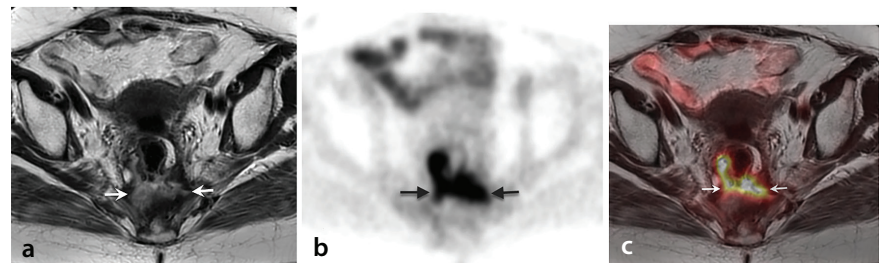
Fluorodeoxyglucose (FDG) uptake in presacral soft tissue after *rectal cancer surgery*. The axial T2-weighted magnetic resonance image (MRI) (a) reveals a lesion of intermediate signal intensity with presacral extension (arrows). The lesion showed diffusion restriction on diffusion-weighted images (not shown). The axial positron emission tomography (PET) (b) and axial fused PET/MRI (c) exhibit high FDG activity (arrows) in the lesion. Pathological FDG accumulation in PET (b) was evaluated in favor of recurrence. A computed tomography-guided fine needle aspiration biopsy confirmed highly hypocellular fibrocollagenous mesenchymal tissue without malignancy.
